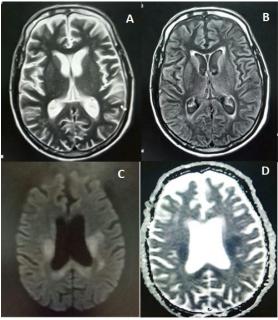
(A): T2WI, (B): FLAIR, (C): DWI, (D): ADC
